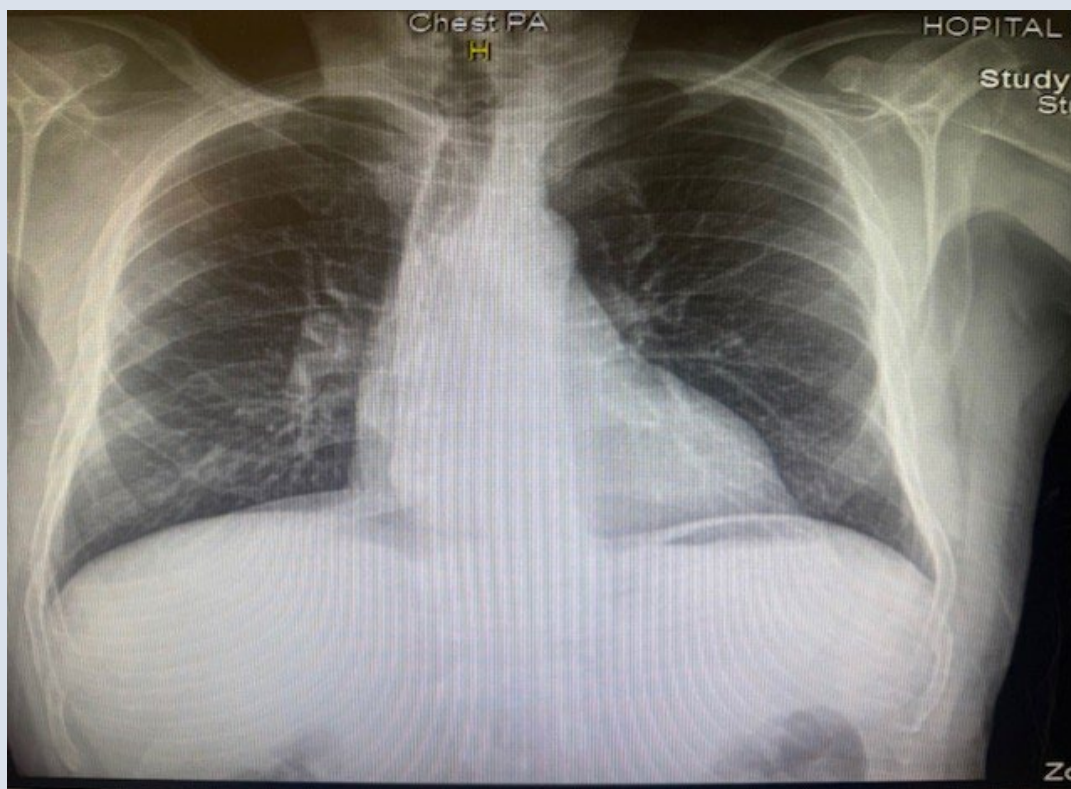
Chest radiograph demonstrating chronic changes consistent with obstructive disease with no focal consolidation, pleural effusion, or acute cardiopulmonary abnormality.
